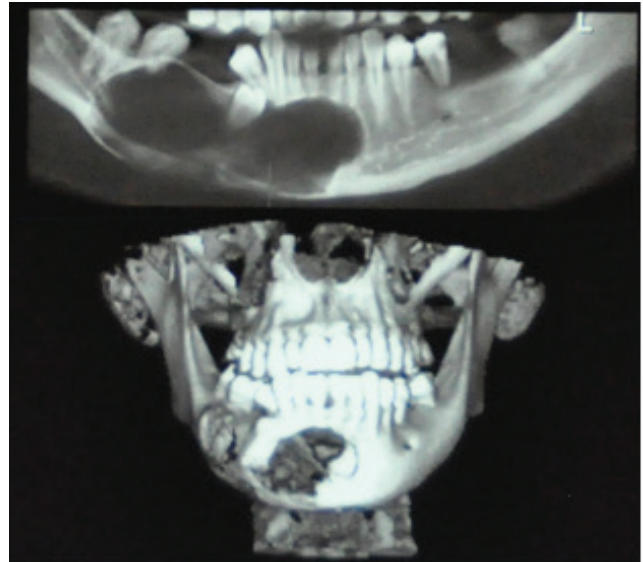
The image of cone-beam computed tomography for odontogenic keratocyst
